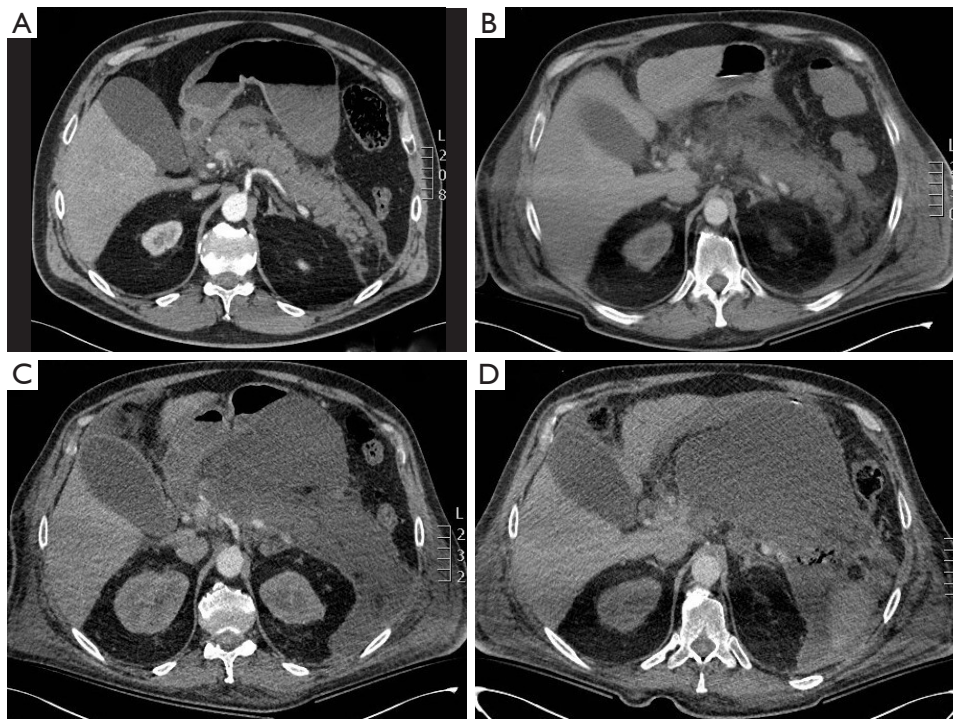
The course of ANP in the same patient in consecutive abdominal contrast-enhanced computed tomography: from pancreatic necrosis (A) in form of acute necrotic collection (B) to infected walled-off pancreatic necrosis (C,D). Scale bar is a radiological reference. L, left side; ANP, acute necrotizing pancreatitis.
